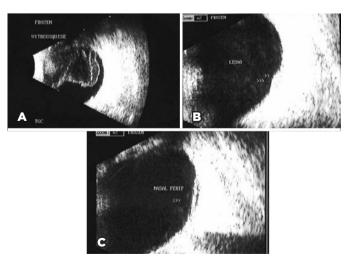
B-scan ultrasound images of toxoplasmic retinochoroiditis (A) Vitreoschisis and total posterior vitreous detachment (PVD). Delamination of the posterior vitreous cortex in two leaflets can be observed. The outermost leaflet corresponds to the posterior hyaloid membrane. (B) Vitritis and a localized elevated lesion corresponding to the site of an exudative lesion without PVD. (C) Localized retinal detachment at the site of the exudative lesion.
